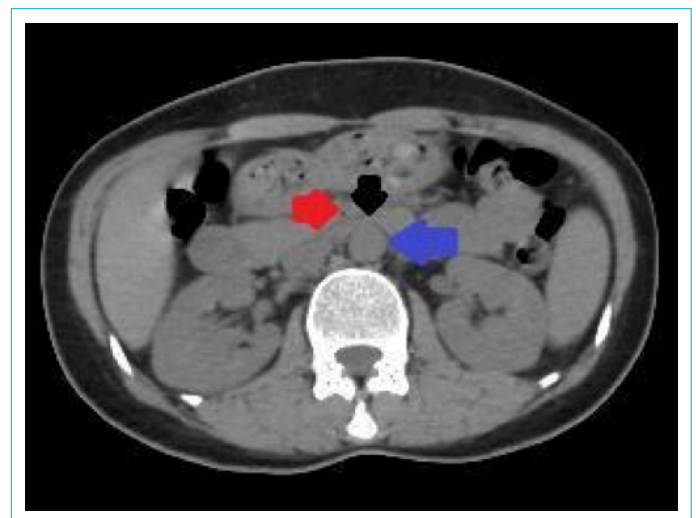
A computed tomography section of the patient. Black arrow: Duodenum; Blue arrow: Aorta; Red arrow: Superior mesenteric artery.
